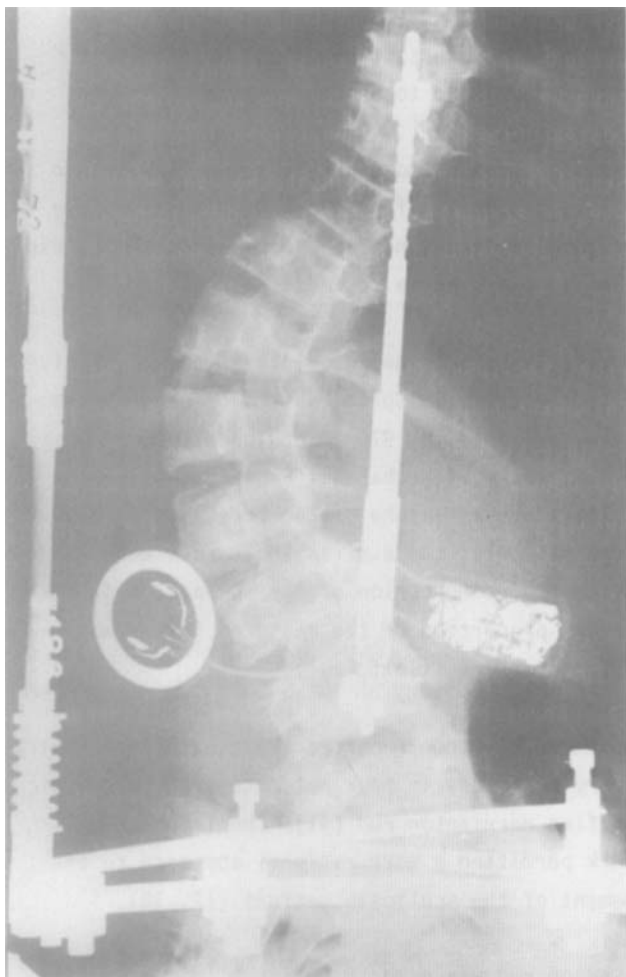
Patient No. 1. Antero-posterior radiograph of patient with paralytic scoliosis. Note the extension bar of the halo-pelvic apparatus with the compression spring at its base in addition to the telemetry rod with the coil and transmitter.
